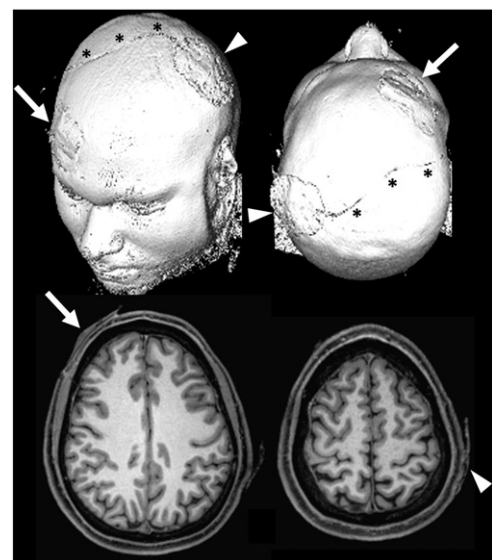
Three-dimensional surface reconstruction (top) and axial cross-sections (bottom) from the T1-weighted anatomical dataset of a single subject. The electrodes over the left-hemispheric M1 hand area (arrowheads) and right-hemispheric orbita (arrows) are indicated. The cable running from the electrode over M1 across the subject's head is marked by asterisks.
